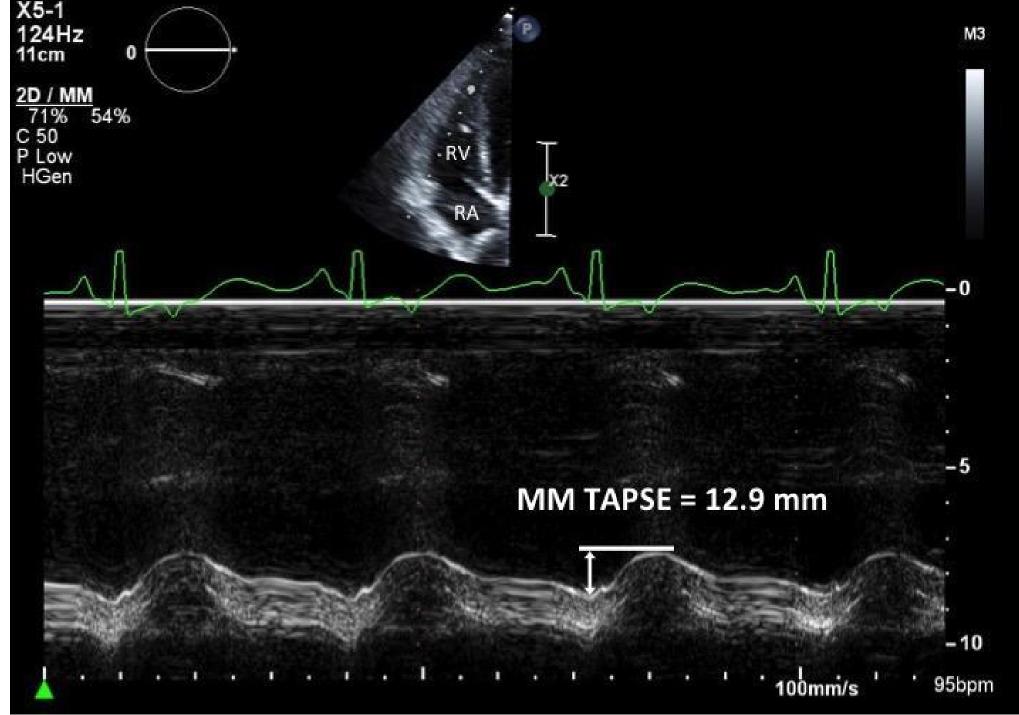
Representative measurement of M-mode echocardiography-derived TAPSE (MM TAPSE).
